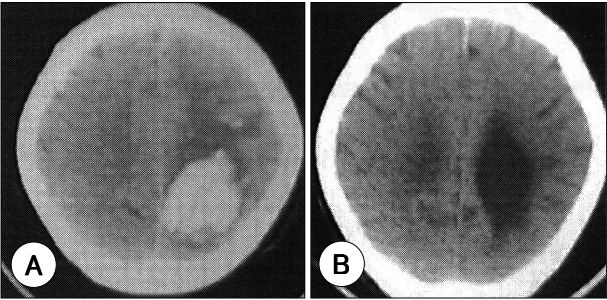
Brain CT scan of case 2. A : Non-contrast CT scan taken in Apr. 1988 revealed intracerebral hemorrhage in left temporo-parietal lobes. B : CT scan showed no new lesion except encephalomacic changes with mild ventricular enlargement in left temporoparietal region when patient had language disturbance in Sep. 1993.
